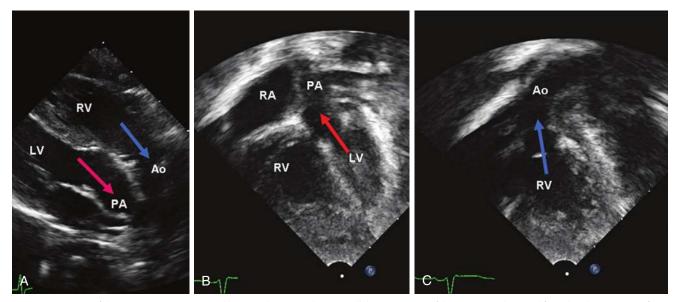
Transposition of the great arteries. Parasternal long axial view (A) shows parallel arrangement of the great vessels. Apical four-chamber views confirm origination of the pulmonary artery (PA) from the left ventricle (LV) (B) and the aorta (Ao) from the right ventricle RV) (C).
